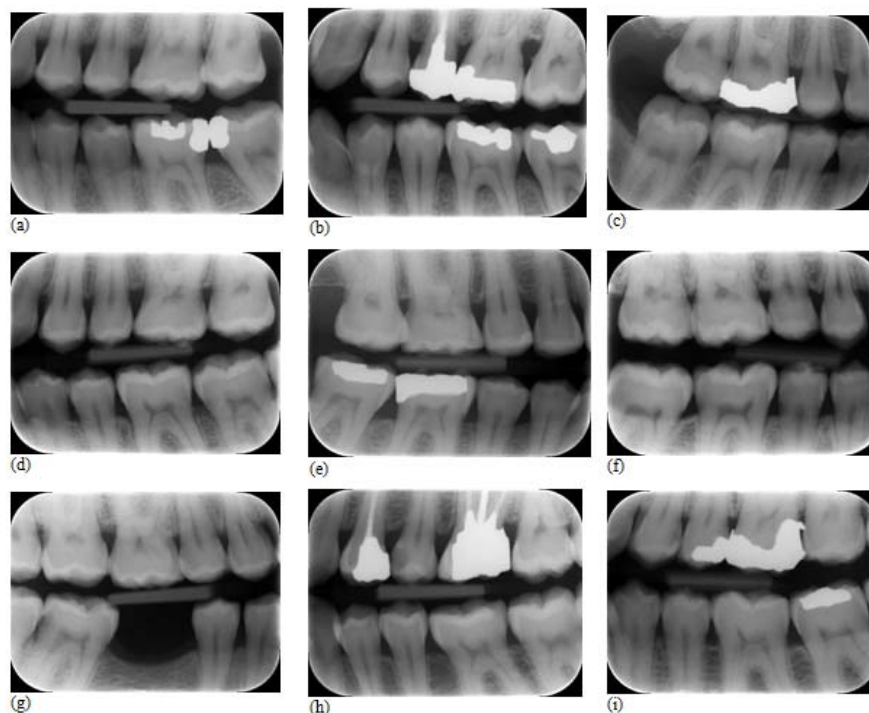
Six radiographs with complete agreement between 8 users (a, b, c, d, e, f). Three radiographs with complete agreement just in coordinates (g, h, i)
